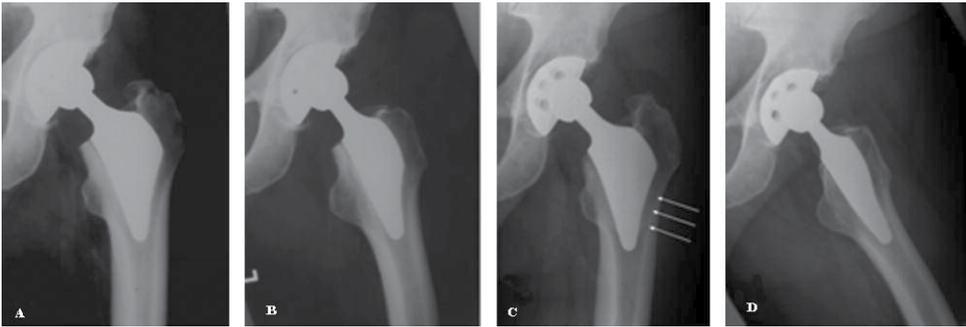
AP and lateral radiographs of a Proxima™ stem in a hard cancellous bone (a-b) immediately after operation (c-d) 24 months post op. The stem is fixed by strong and compact cancellous bone, without loosening.
